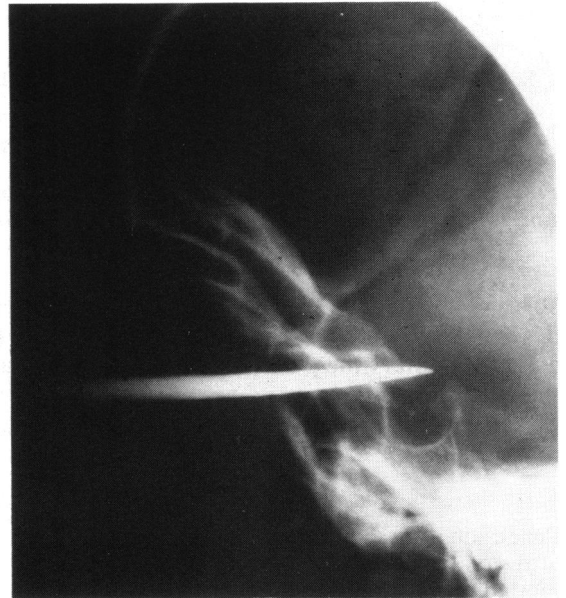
Lateral skull radiograph.
